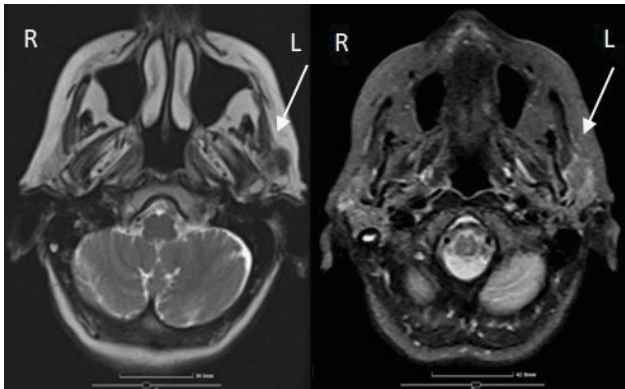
Head MRI without contrast showing an expansile 3x15 cm tumorous lesion of the anterosuperior aspect of the left parotid
